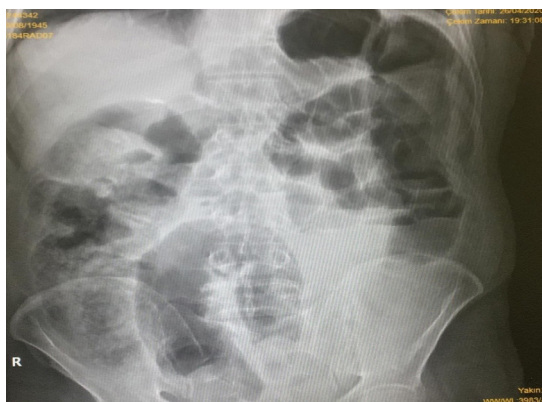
Air -fluid levels in standing direct abdominal radiography
